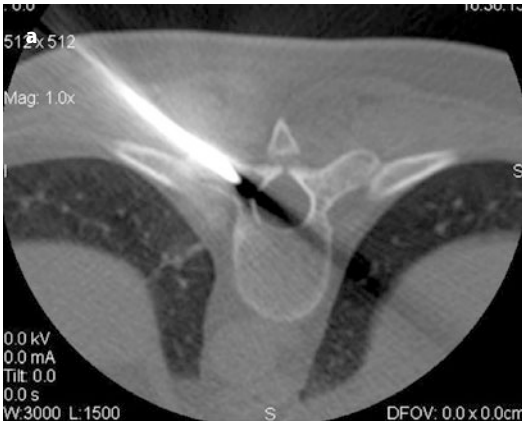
Pedicle augmentation in a female with painful focal left pain at the T6 level. Before augmentation, a lytic lesion of the left transverse process related to localization of breast cancer metastases can be seen (a). After PMMA injection, total filling of the left transverse process can be observed on axial, sagittal and coronal CT reconstruction, with resolution of the pain (b)
